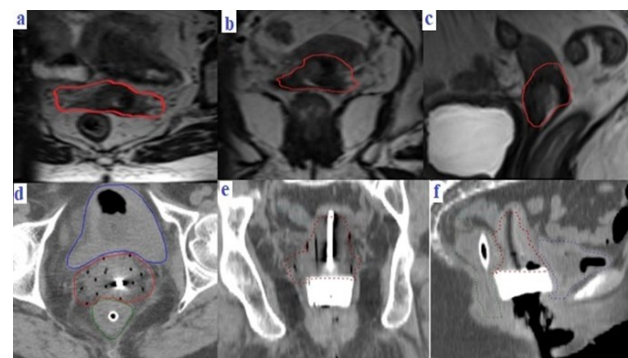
Delineation of HRCTV and normal structures by using pre-brachytherapy MRI in (a) axial view (b) coronal view (c) sagittal view and with applicator in CT scan (d) axial view (e) coronal view (f) sagittal view.
